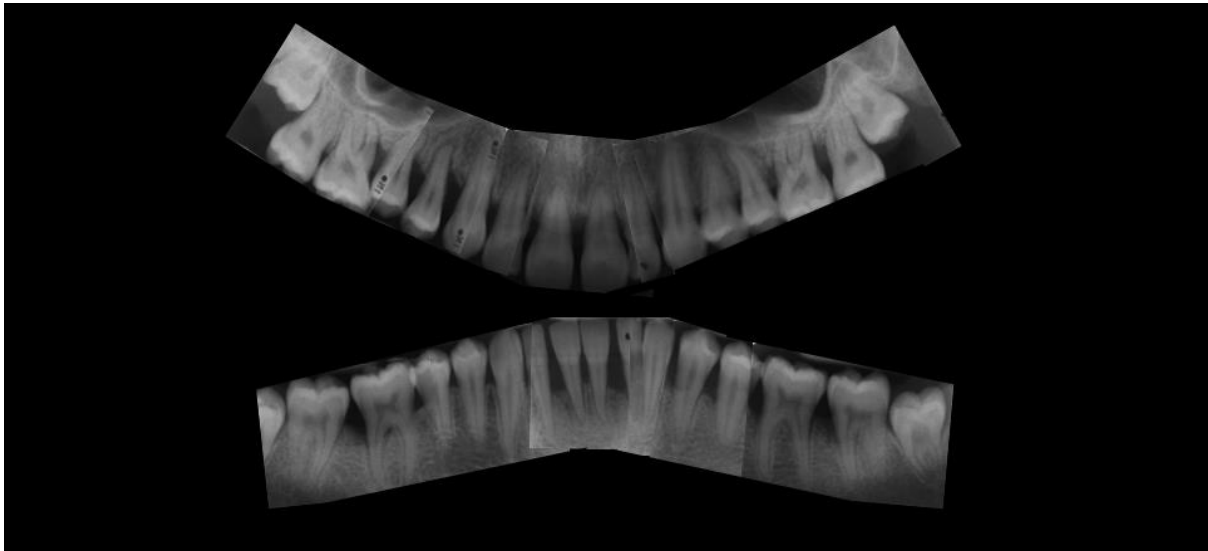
Case 1 - Periapical intraoral radiographs.
